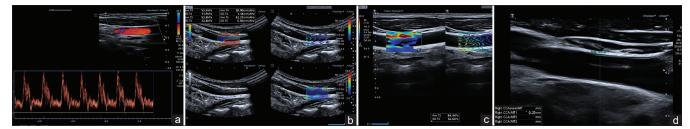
(a) Color Doppler image of the common carotid artery showing normal waveform and peak systolic velocity, (b) shear wave elastography (SWE) of the left common carotid artery showing increased wall stiffness (53 Kpa) with increased dispersion of 30 m/s/Khz (arrow). (c) SWE of the right common carotid artery with increased wall stiffening of the anterior wall — 80 Kpa (arrow). (d) Gray-scale image of common carotid with normal intima—media thickness of 0.25 mm
